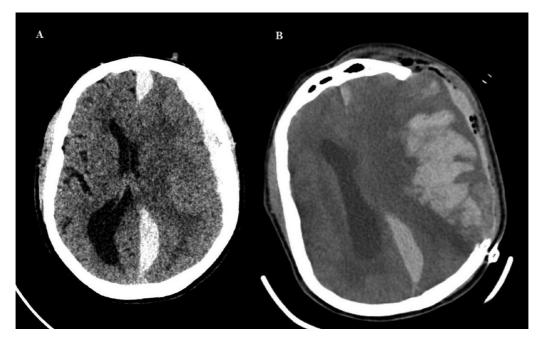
New ipsilateral hematoma. Noncontrast CT head showing (A) left temporoparietal acute SDH with a thickness of 1 cm and a midline shift of 9 mm. (B) Postcraniectomy with bleed in the ipsilateral cerebral hemisphere with significant mass effect.
